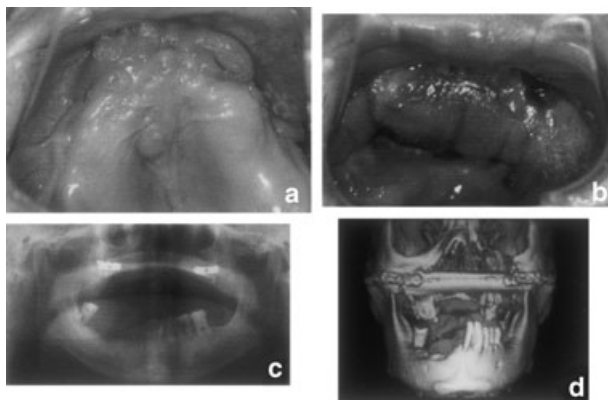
Intraoral condition before and after the surgery. (a) The maxilla before surgery. (b) Intraoral view of reconstructed maxilla 18 days after the surgery. (c) Orthopantomograph after the surgery. (d) A reconstructed image of computer tomography after the surgery.
